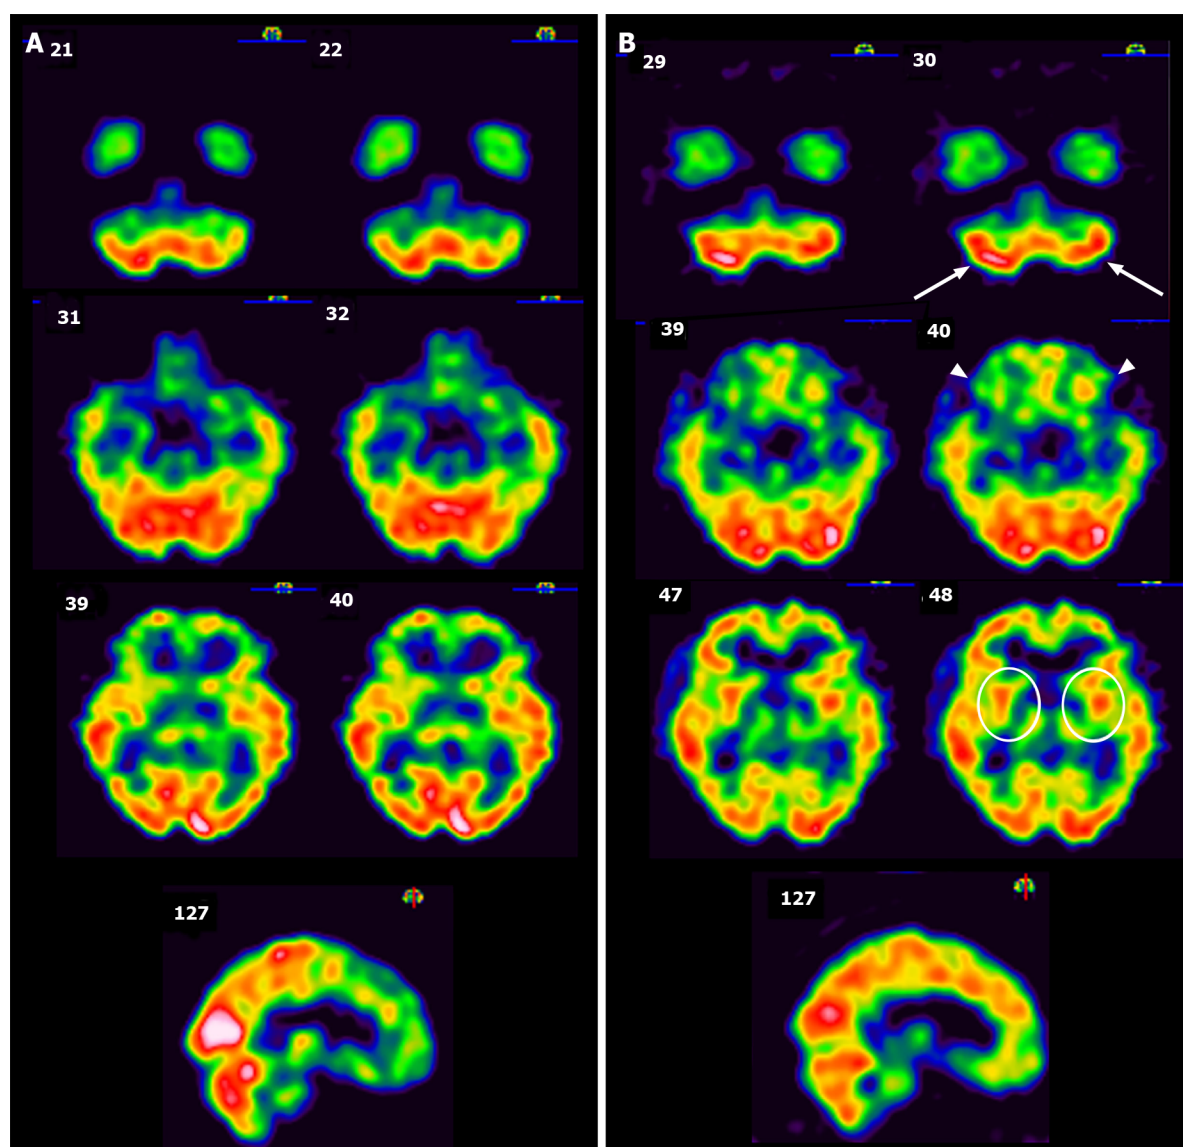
Technetium-99m ethyl cysteinate dimer single-photon emission computed tomography images of the patient. A: Single-photon emission computed tomography images before intravascular laser irradiation of blood therapy. Prominent hypoperfusion can be seen in the axial views of the left cerebellum, bilateral frontal lobe, and bilateral striata (from top row to bottom row). The sagittal view shows hypoperfusion in the parietal lobe and frontal lobe; B: Follow-up single-photon emission computed tomography images after 3 courses of intravascular laser irradiation of blood. Greatly improved perfusion can be seen in the bilateral cerebellum (arrow), bilateral frontal lobe (arrowhead), bilateral striata (circle), and parietal lobe (sagittal view). Intensity of photon uptake is shown in color, e.g., white represents the strongest signal intensity and thus greater perfusion, followed by red, yellow, green, blue, and finally black.
